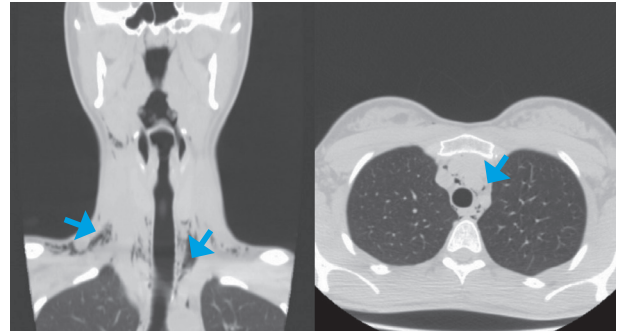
Neck and chest computed tomography shows pneumomediastinum with free air dissecting through the neck, causing significant subcutaneous emphysema (arrows). There is no concomitant pneumothorax. No specific cause is identified.
